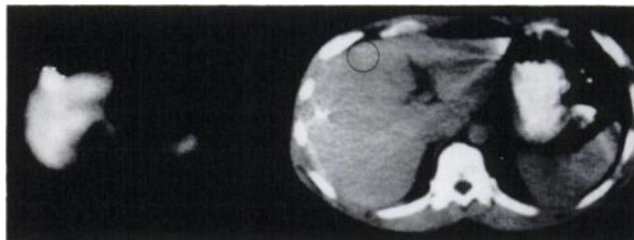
Transaxial SPECT image of ^{111}In -C110 anti-CEA Mab (left), showing an area of high uptake in a surgically confirmed metastatic colorectal cancer (12 o'clock), in an area that is completely without evidence of tumor on the transaxial CT scan (right). The circle on the CT scan corresponds to the region in question. Reproduced from Kramer and Noz (74) with permission of the publisher.
